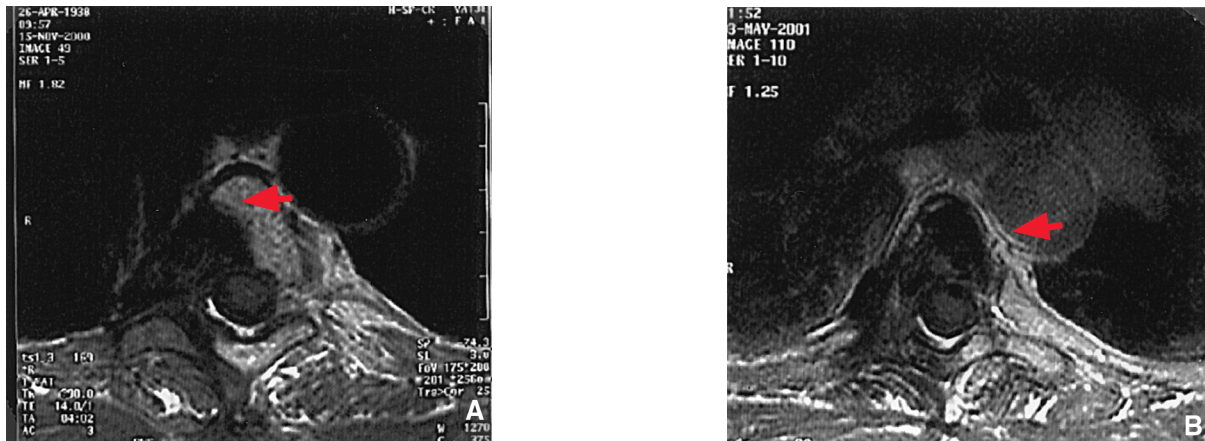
A, Magnetic resonance image of vertebral body T4 shows the status before radiofrequency ablation (RFA). The osteolytic tumor mass can be clearly identified (arrow). B, The same segment 6.5 months after RFA. The tumor has been ablated, and there is no visible tumor progression in vertebral as well as in paravertebral structures and the pleura. The remaining vertebral body has been filled with polymethyl methacrylate (arrow).
